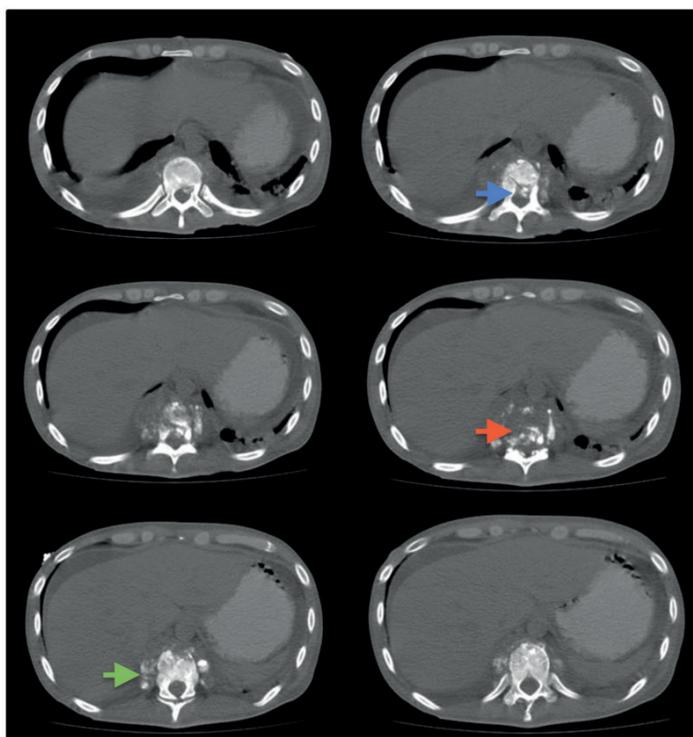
Chest CT scan: T10 and T11 vertebral destruction (red arrow) with a thickening of the paravertebral soft tissues (green arrow) and the displacement of bone fragments into the medullary canal (blue arrow).
